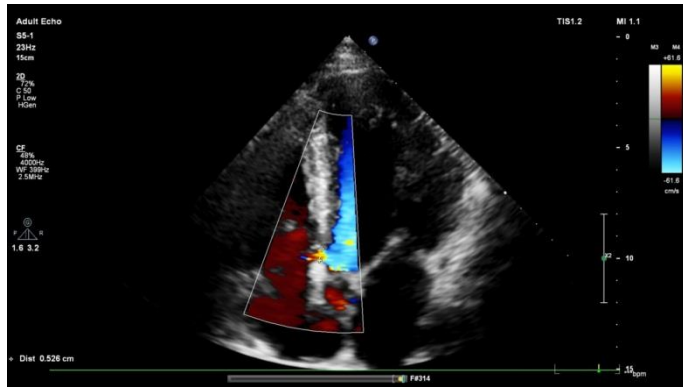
Two-dimensional echocardiographic image
